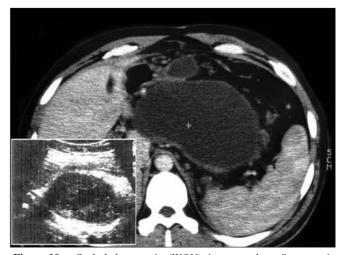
Secluded necrosis (WON) interpreted as "pancreatic pseudocyst" in a male patient (AC) with severe acute pancreatitis, 4 weeks after onset. Ultrasound (box): giant heterogeneous secluded collection, mixed content. Intraoperative is found a mixed collection: pus, pancreatic and peripancreatic necrosis
